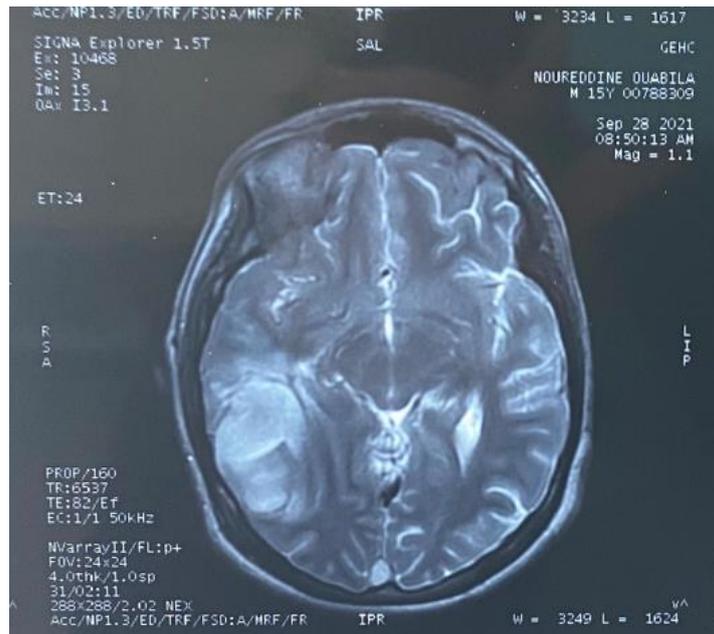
Brain MRI showing cerebral vein thrombosis
